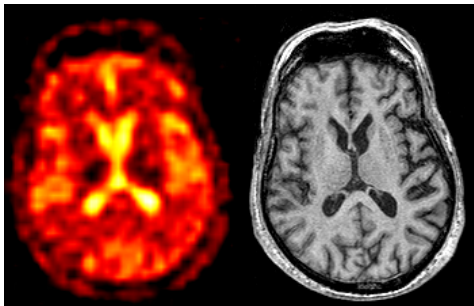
Coregistered sodium (left) and T1-weighted (right) images.
